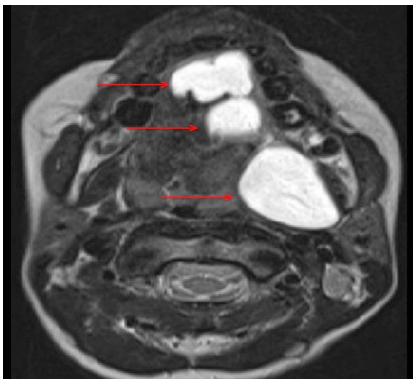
MRI with contrast showed a left multilocular neck lesion anterior and superior to the sternocleidomastoid muscle with enhancing tissue extending to the submucosal left tonsillar fossa. The lesion consisted of multilocular (red arrows), homogenous masses (8.0 cm x 5.0 cm in maximum diameter), which were consistent with cystic lesions.
